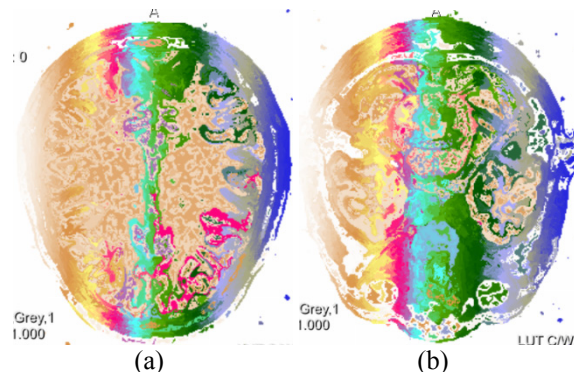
Color representation of regions resulting from AII4_WS. The MRI morphology is cognizable for slices #146 (a) and #55 (b) of dataset [1]sj04.
